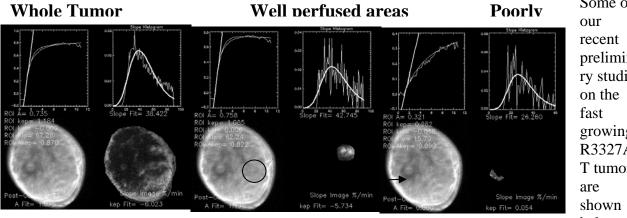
Dynamic contrast enhanced MRI obtained after injection of Gd-DTPA. Acquisition parameters include FOV = 3.0x3.0cm; 128x128 matrix; St=2.0mm (single slice, Coronal); TR/TE/ $\theta$  =  $50/2.5/30^{\circ}$ ; 12 sec/image; 55 time pts; total ~11 min acquisition time. Left figure shows data from the whole tumor and shows the signal intensity vs time graph, a histogram of the slope of all the pixels, a post contrast image and a parametric image of the parameter Ak<sub>ep</sub>. The middle and left figures are similar but correspond to well perfused and poorly perfused regions.
